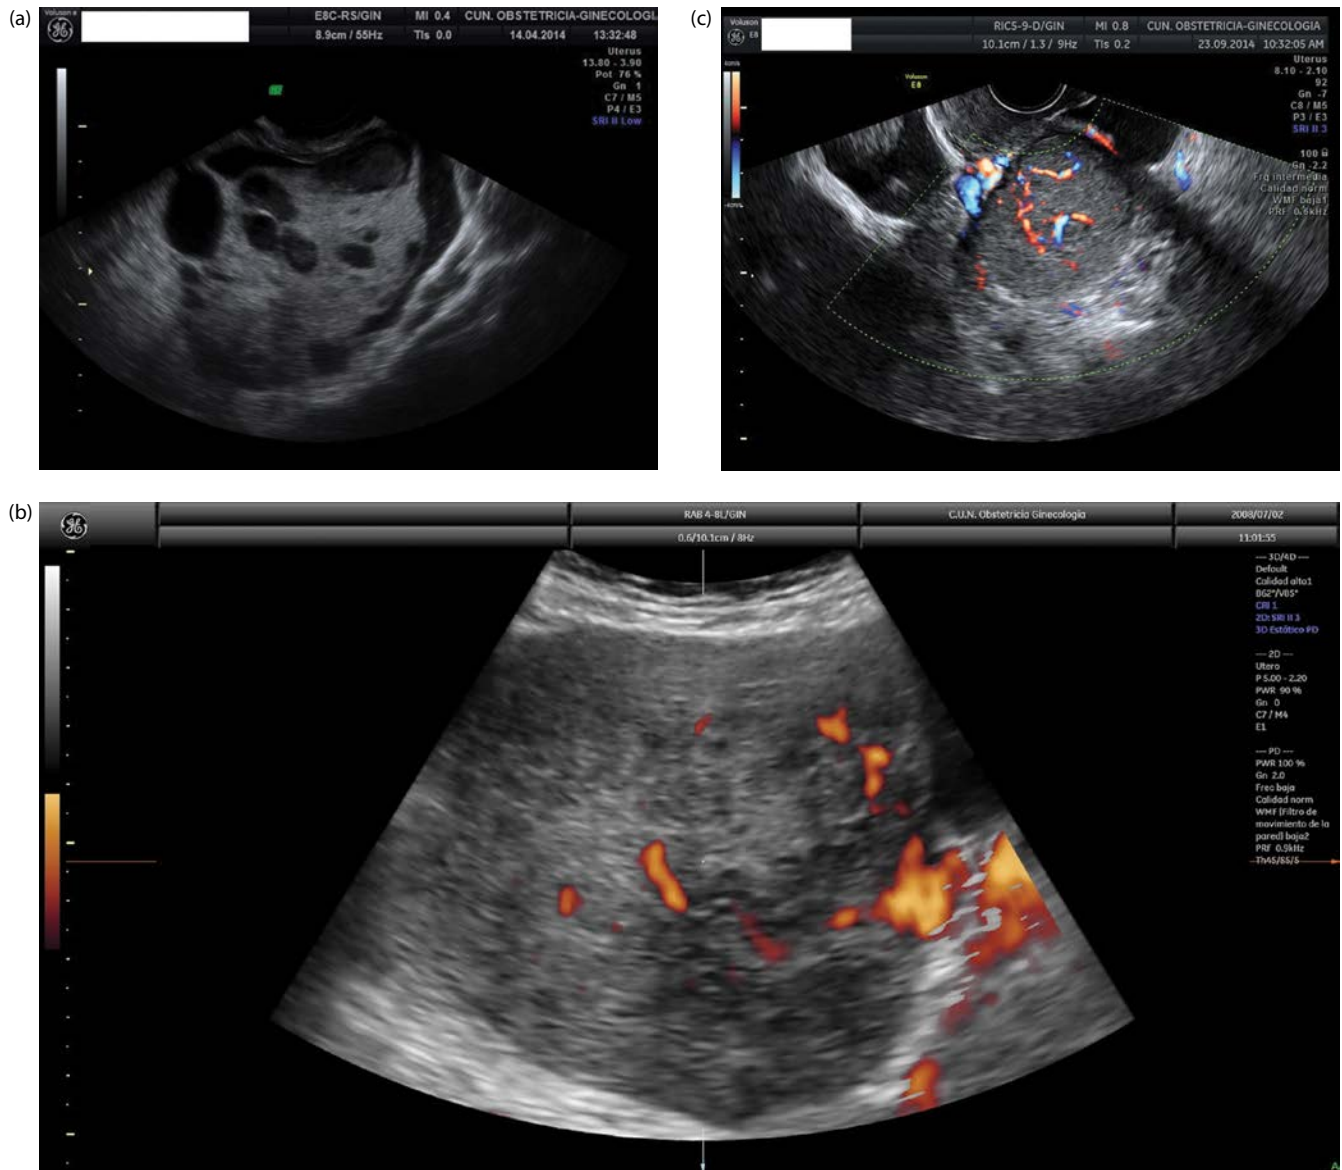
Ultrasound images from metastatic tumors to the ovary. (a) Metastasis from a colorectal carcinoma showing a solid mass with cystic areas. (b) Metastasis from a gastric cancer showing a large, solid mass with abundant vascularization. (c) Metastasis from a breast cancer showing a small, solid mass with abundant vascularization.
